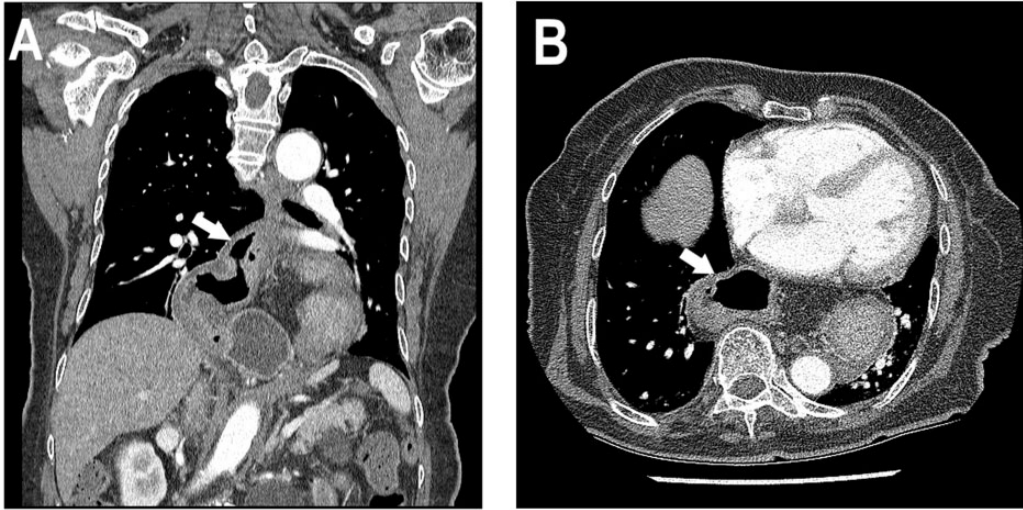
Computed tomography scans of coronal (A) and transverse sections (B) show a large hernia sac (white arrow) in the posterior mediastinum
